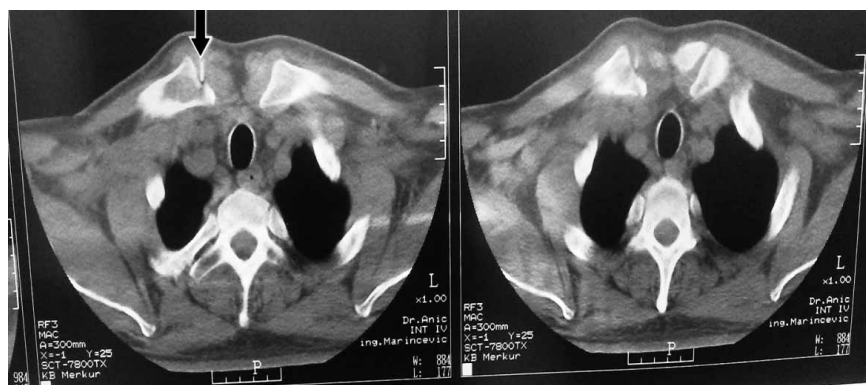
CT scan of sternoclavicular joints shows a needle in the right sternoclavicular joint while taking sample of synovial fluid for cytologic analysis.
